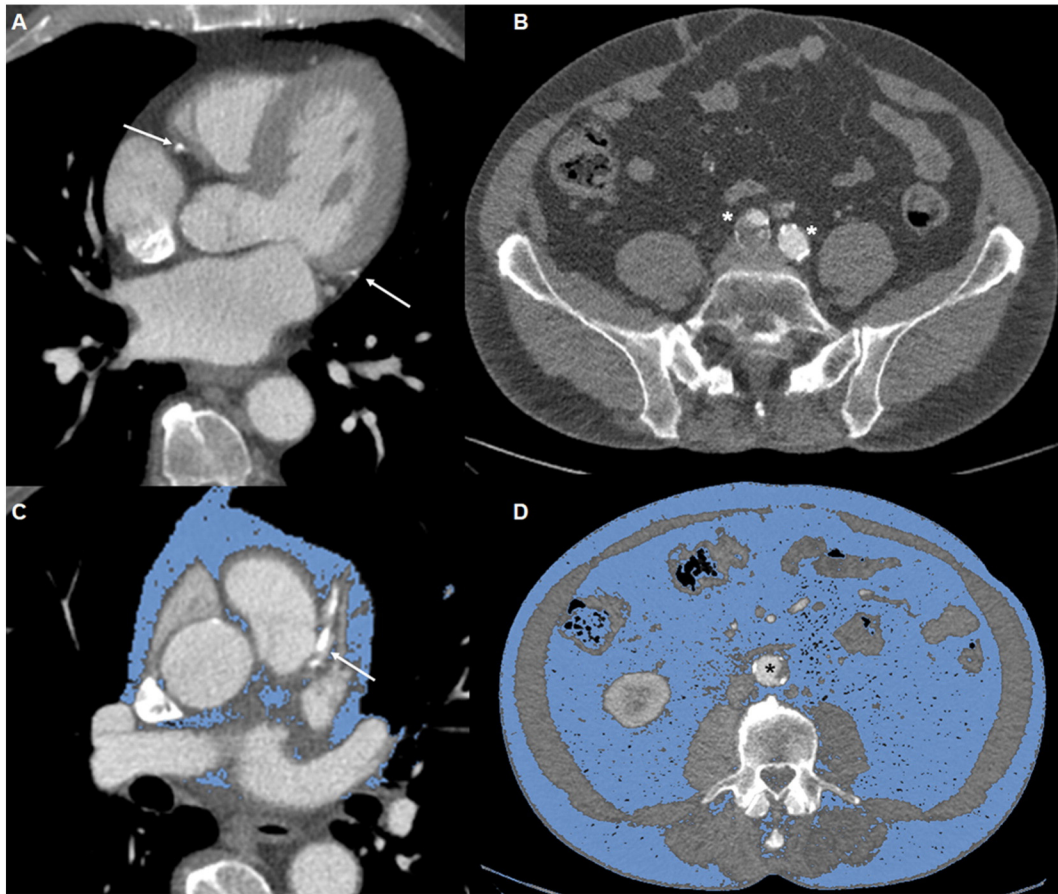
Male with normal BMI, large visceral fat and extensive plaque burden. Sixty-four year-old male with CTA indicated for a dilated aorta, and diabetes and hypertension as risk factors. His BMI is 22.4 kg/m² (1.89 m, 80 kg). However, he has very extensive coronary (coronary SIS 13, arrows in panels A and C) and extra-coronary (extra-coronary SS 15.7, * in panels B and D) plaque burden. Total body FV was 8333 cm³/m², pericardial FV 99 cm³/m², and abdominal FV 6088 cm³/m², of which 75% was visceral.
